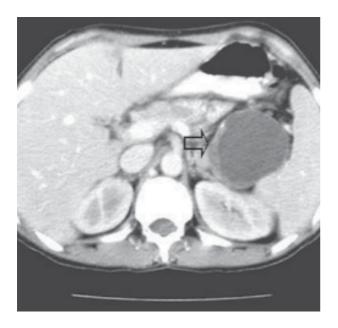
CT scan of the abdomen shows a 7.0-x 6.5-cm cystic pancreatic mass with an enhancing rim of solid component (arrow).
